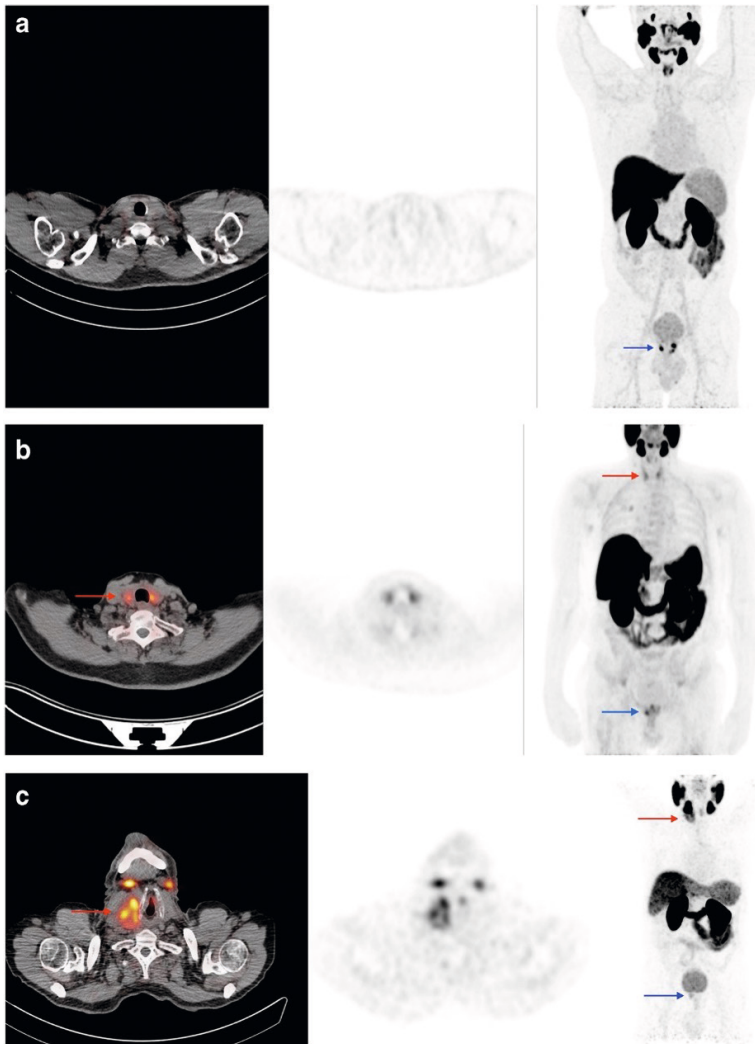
Example images of prostate-specific membrane antigen (PSMA) thyroid incidentaloma (PTI) with focal, irregular, and diffuse patterns and varying level of intensity. Transverse, transverse fused to low-dose CT, and maximum intensity projection (MIP) images of PSMA PET scans are shown. Applied window with SUV_{max} 0–7.
